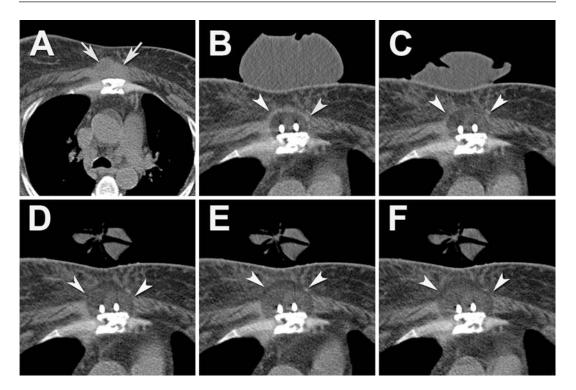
(a) Axial non-contrast CT demonstrates breast cancer metastasis to the lower sternum and overlying soft tissues (*arrows*). (b–f) Cryoprobes placed along the superficial aspect of the sternum through the soft tissue
